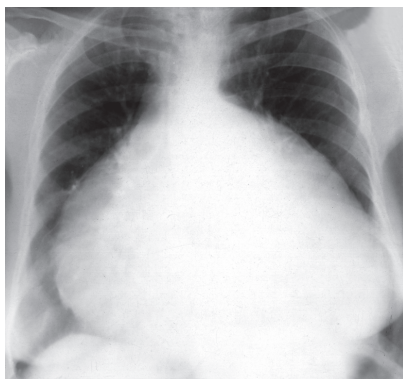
Frontal X-ray. Pericardial effusion
